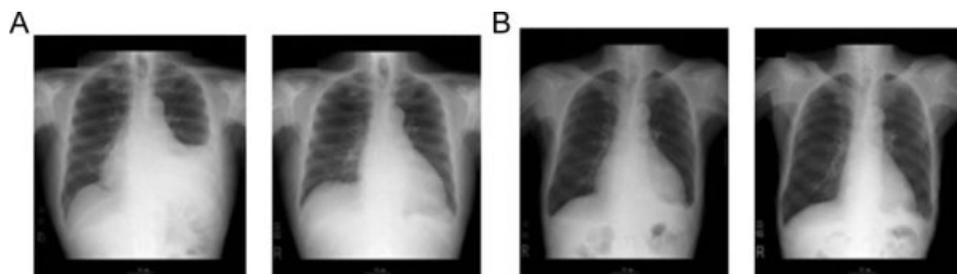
Chest X-rays of the cases. A: Chest X-rays when case 1 was diagnosed (left panel) and now (right panel). B: Chest X-rays when case 2 was diagnosed (left panel) and now (right panel).
